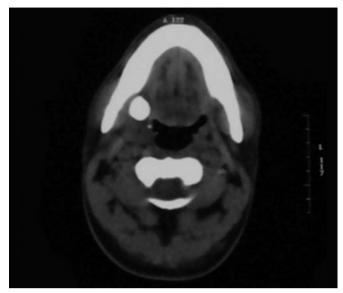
Computed tomography scan of the right submandibular gland showing calculus.
